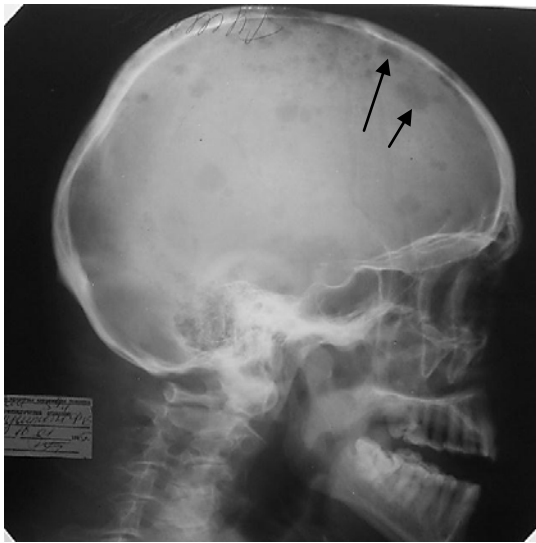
The survey radiograph of the skull in a lateral projection. Multiple sites of destruction of various sizes and round form with distinct contours in bones of the skull (arrows) are defined. Multiple (plasma cell) myeloma is detected
